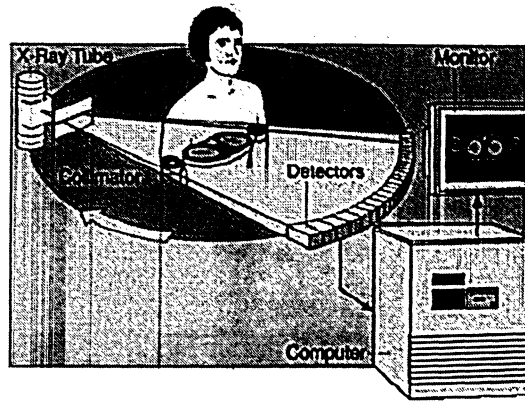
Fundamentals of a CT scanner (Extracted from Imaginis the Breast Cancer Resource).
